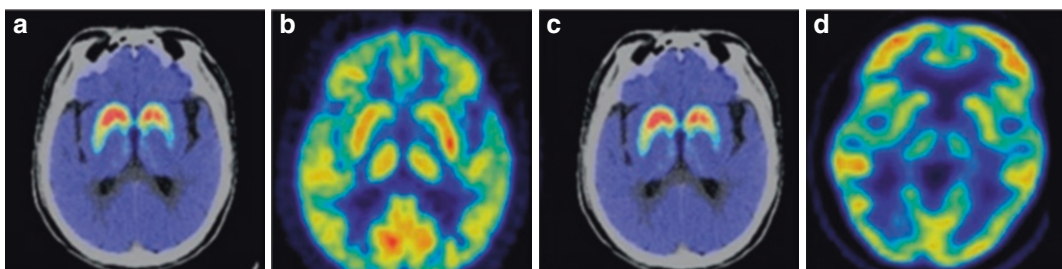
DAT and FDG PET findings of patients with PD and MSA. A 64-year-old male patient with PD, whose chief complaint was involuntary tremors of the right limbs for more than 1 year. Transverse PET showed reduced DAT distribution in the bilateral putamen, with significant reductions in the left, and increased glucose metabolism
